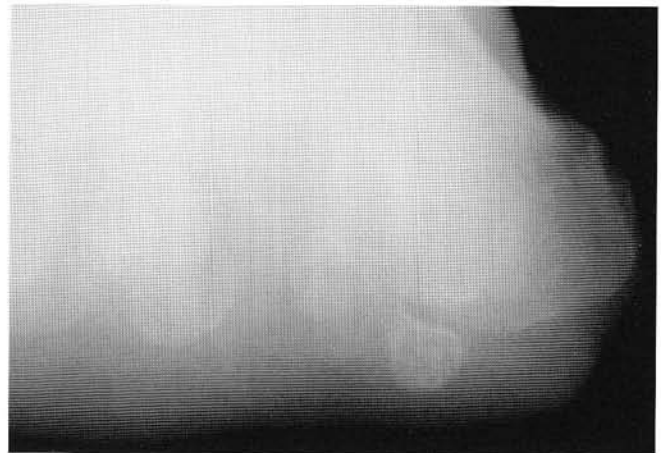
Radiograph shows valgus rotation of the sesamoids. Note the medial cortical wall of the first metatarsal is not rotated.
